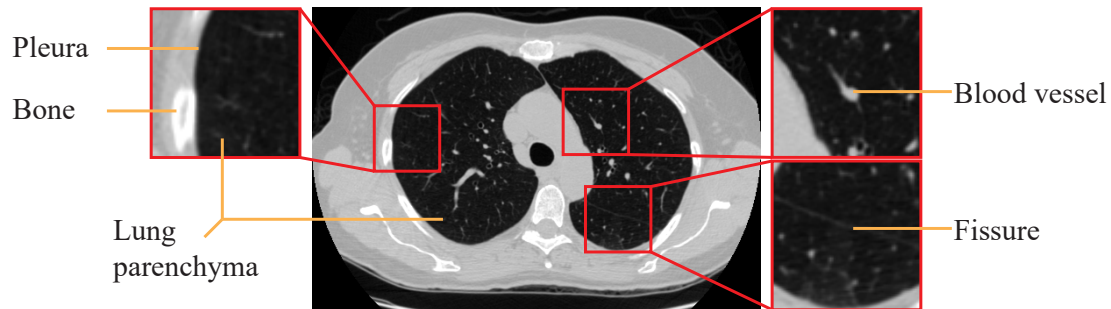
Example of a slice from a CT scan. Relevant structures (blood vessels, bone, fissures and lung parenchyma) are depicted. CT scan image from TheCancerImagingArchiveTeam.
